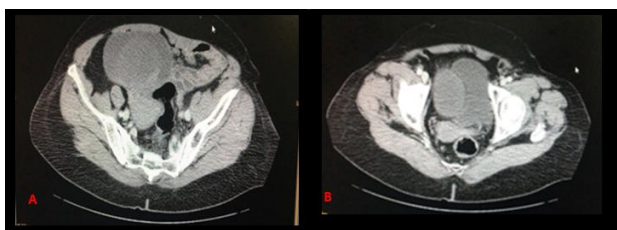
Figure A-B: CT AP, Axial section showing a large solidocystic right lateral mass of 120/82/145 mm and ovarian vesical probably of ovarian origin
